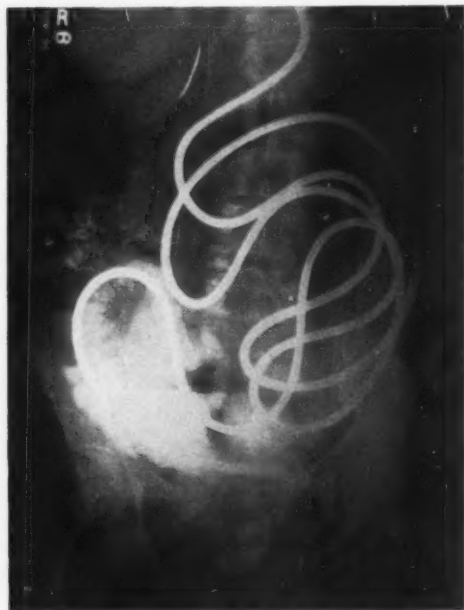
X-ray taken 1-14-49. Note that the barium sulphate as well as the intestinal distension has almost entirely disappeared. 3000 c.c. of intestinal contents were aspirated by means of this tube each day.
